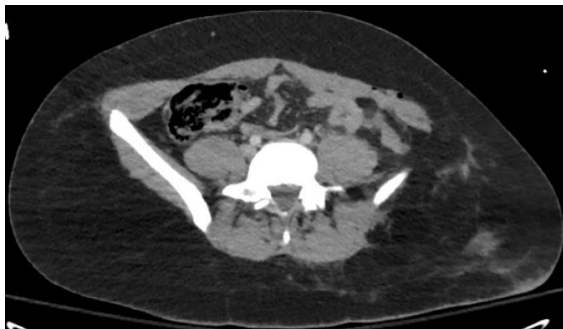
An axial view of a CT image showing a left parailiac flank hernia without intra-abdominal contents.
